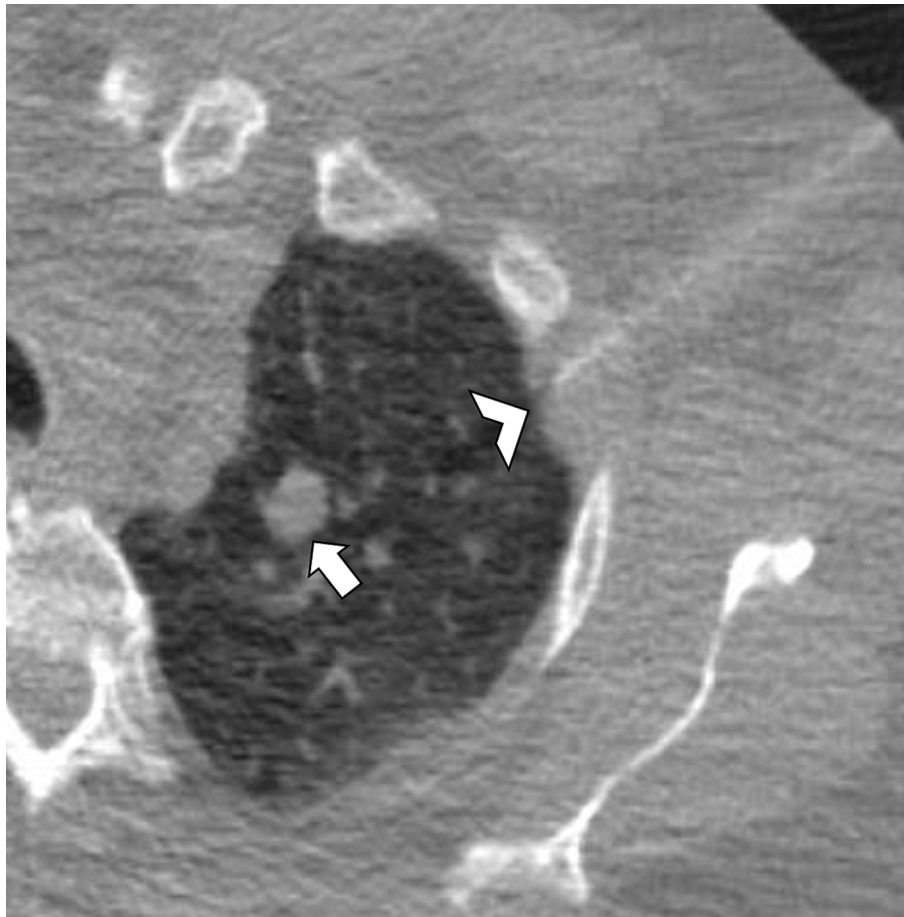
Anesthesia administration during a CT-guided transthoracic core needle biopsy of a solid nodule located in the left upper lobe (arrow). The needle trajectory was oriented toward the target, and anesthesia was delivered at the pleural surface (arrowhead) without penetrating the lung parenchyma.
